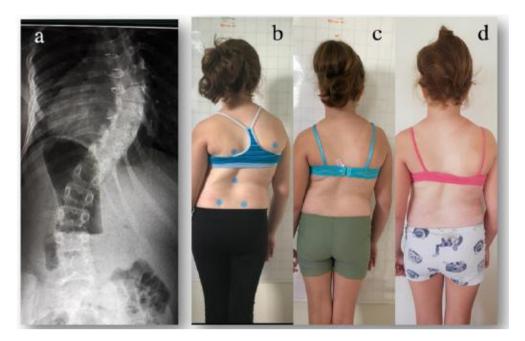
The patient with two operations for CHD with a collapsing spine at the age of 9.9 years at the start of treatment. (a) x-ray taken November 2019 with a Cobb angle of approx. 65° Cobb, (b) picture from the same time showing the patient from the rear with a collapsing spine. (c) after the application of the Schroth Best Practice Program while waiting for the brace and (d) after a few nights spent in the brace (Weiss et al. 2021b).
